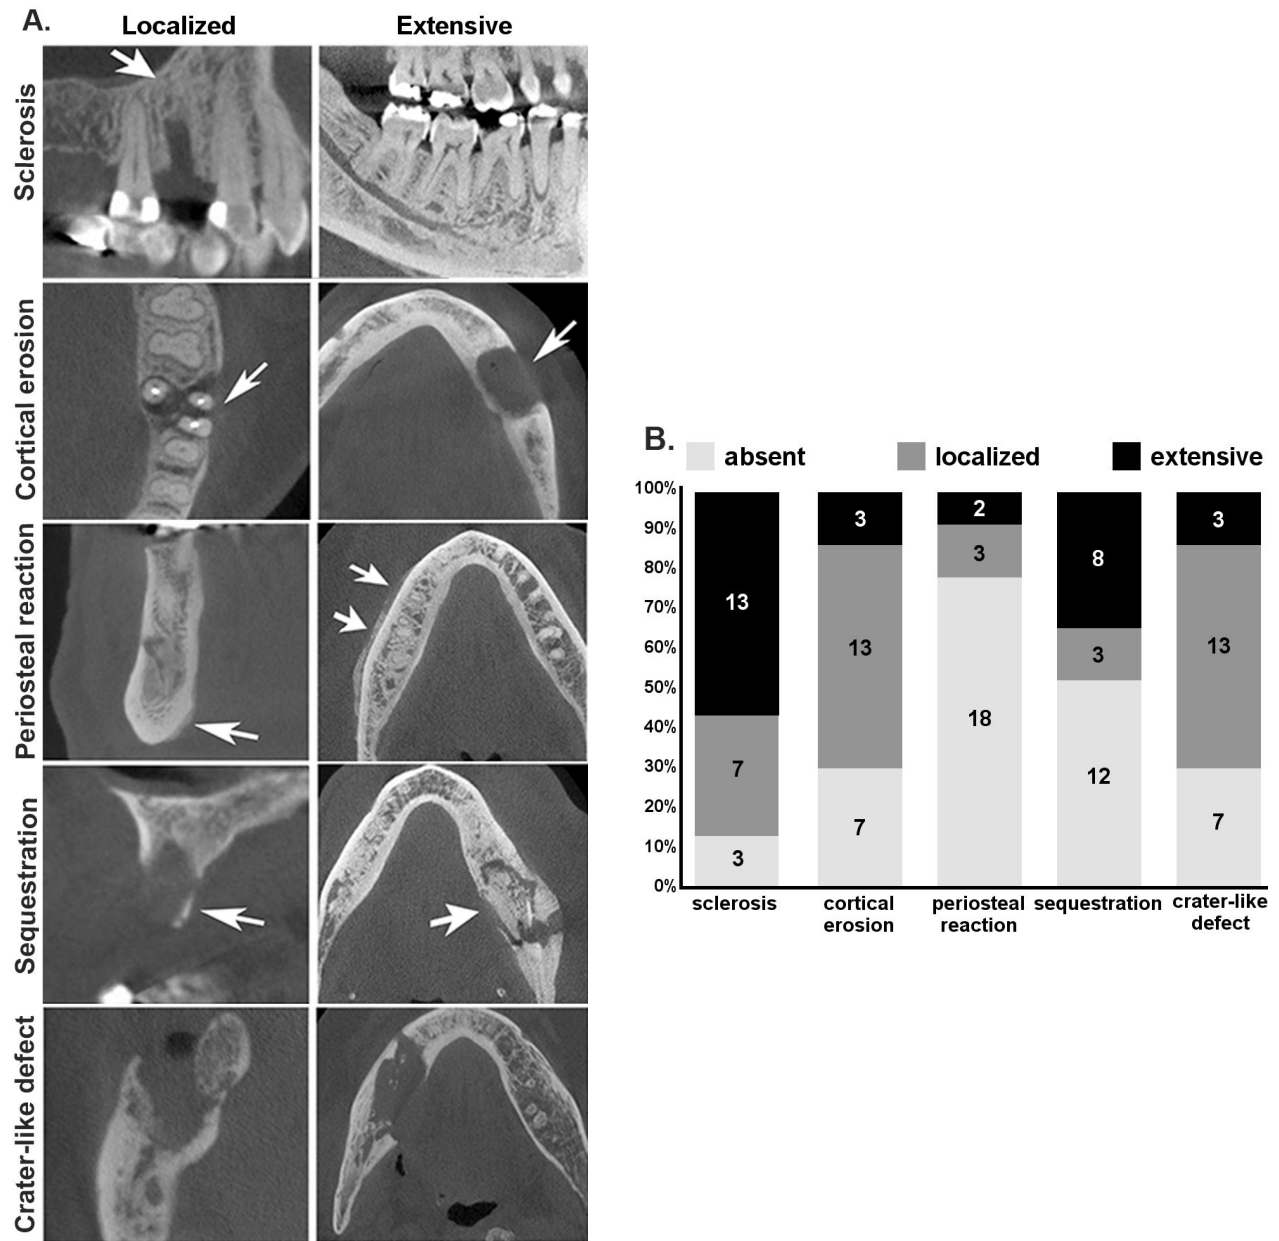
Radiographic assessment. Representative examples of localized or extensive Trabecular Sclerosis, Cortical erosion, Periosteal reaction, Sequestration, Crater-like defect (A). Incidence and extent of these radiographic parameters in all patients (B)
